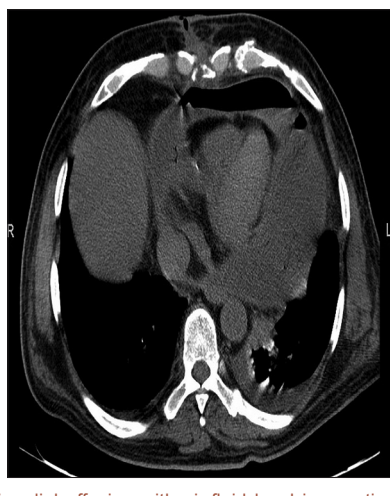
Pericardial effusion with air-fluid level in a patient with previous Implantable Cardiac Defibrillator (non-contrast chest CT. Mediastinal window)
